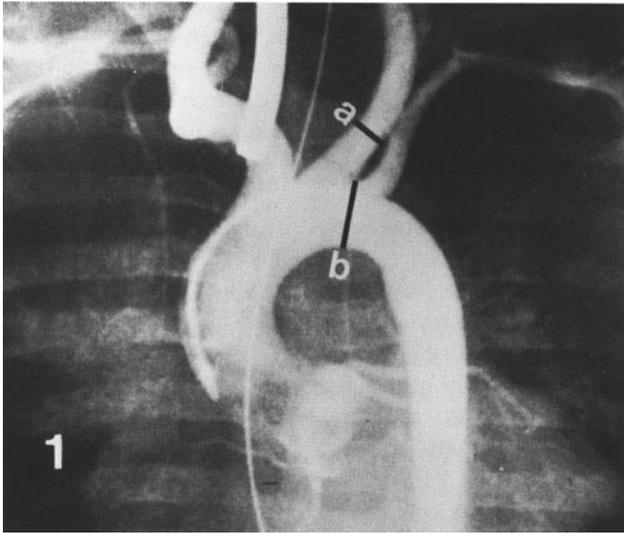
(1) Cineangiogram, normal (*a*, LCCA; *b* TAA). (2) Two-dimensional echocardiogram, normal (*a*, LCCA; *b*, TAA).
